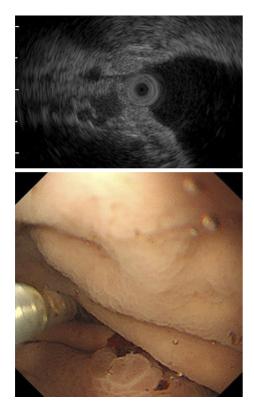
Endoscopic ultrasonography at 12.0 MHz from an endoscopic view. Crater-like, hypoechoic mucosal collapsed point. This was connected to the gastric submucosal vessels.
